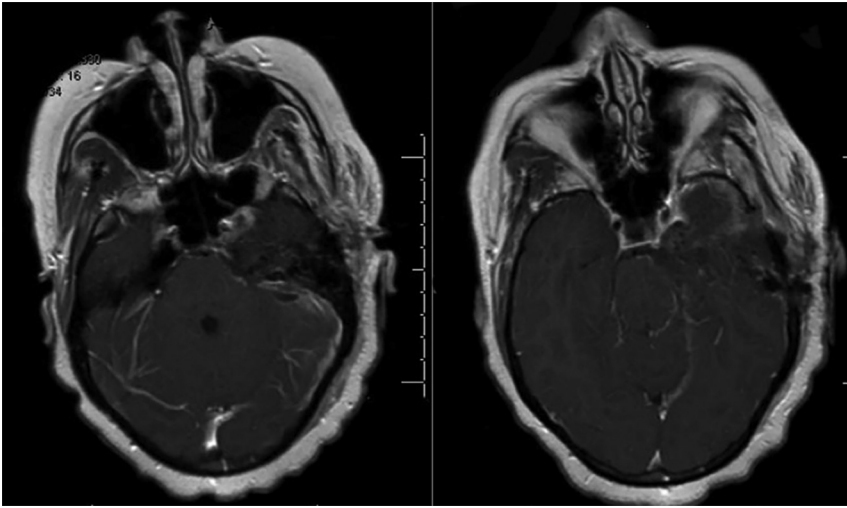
Postoperative MRI. Axial MRI with gadolinium showing a complete resection of the Meckel's cave schwannoma with decompression of the brainstem.
